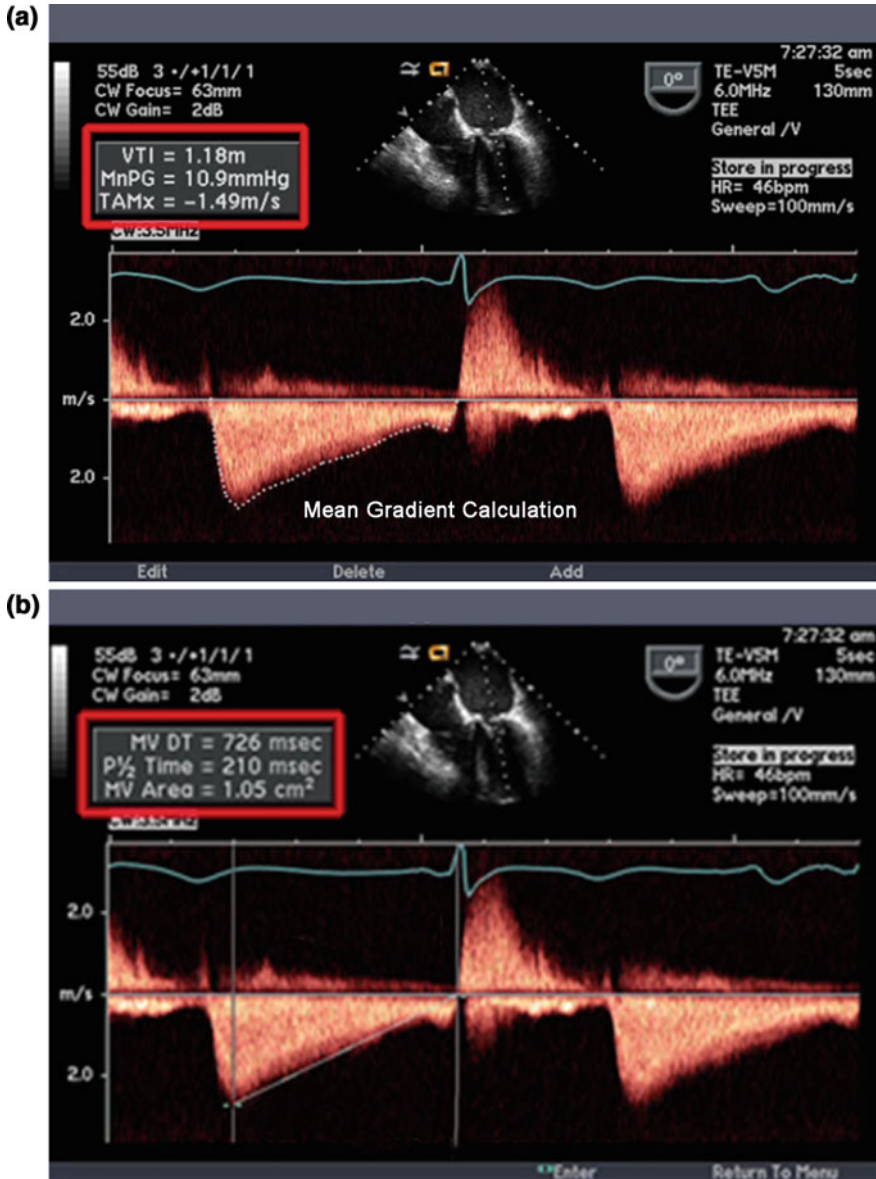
a Continuous wave Doppler interrogation across the mitral valve. The mean gradient of the transmitral flow profile is calculated by tracing the entire envelope or velocity time integral. b The spectral Doppler profile is characterized by a high velocity E-wave with a prolonged pressure half time or deceleration time, which can be used to calculate the mitral valve area
